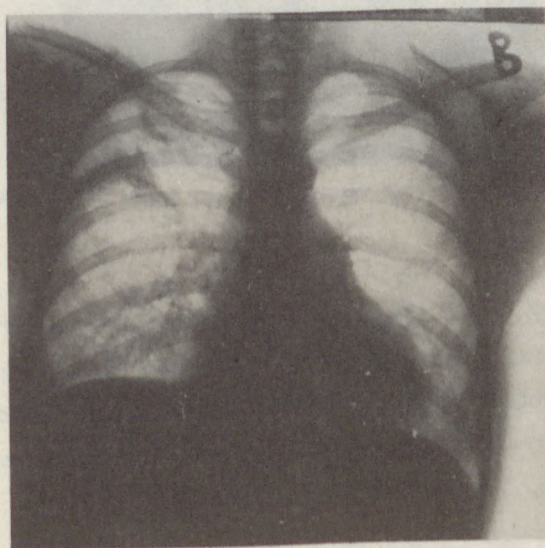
Thoracic X-ray picture of H.J. (case 1) on day 4 of treatment
